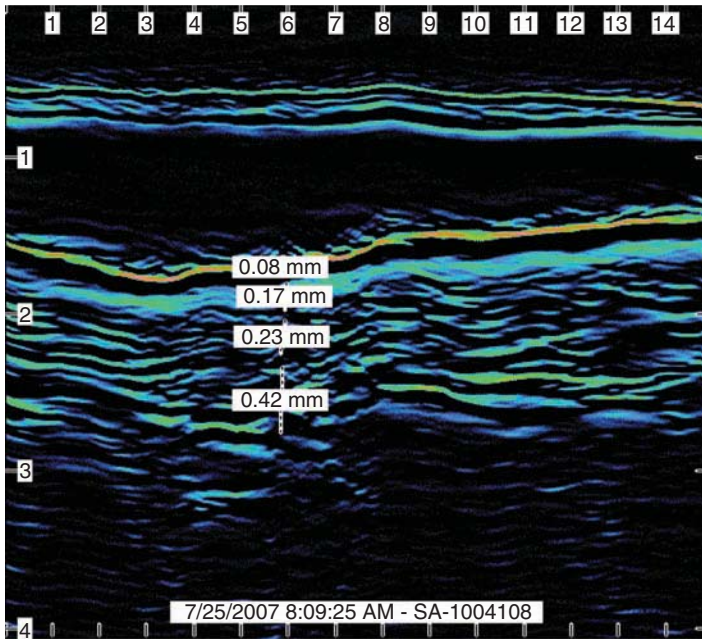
Ultrasound image of the lower leg skin 2-weeks after treatment with an effective skin anti-aging product showing an increase in epidermal thickness and density of dermal elastin/collagen fibers. (Source: Essex Testing Clinic, Inc., Verona, NJ)
